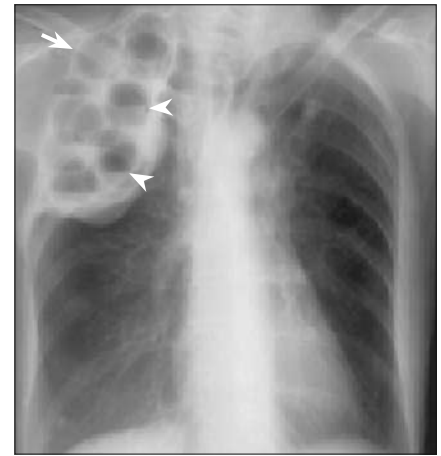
Plombage. A frontal chest radiograph demonstrates typical right-sided Lucite ball plombage. There is thinning and disorganization of the overlying ribs (arrow). Air-fluid levels in the Lucite balls (arrowheads) suggest broncho-pleural fistulas. Reprinted with permission from *Radiographics* (1).
